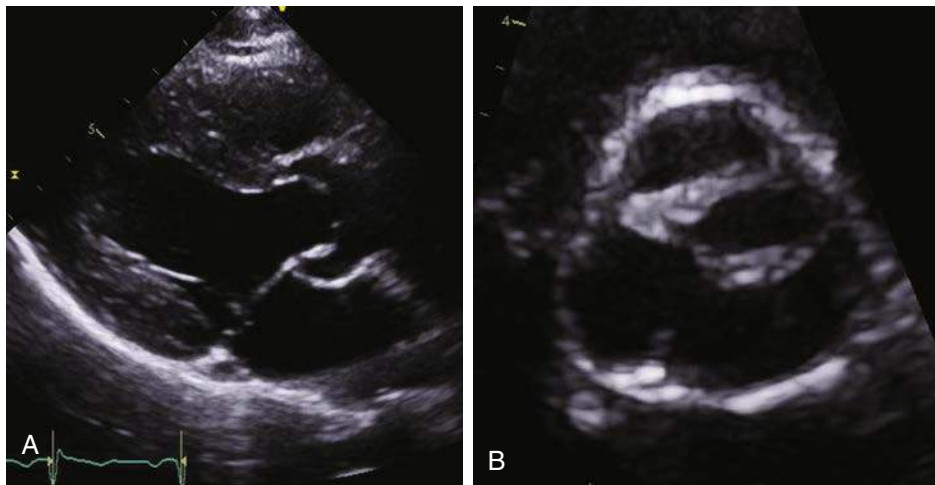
Two-dimensional transthoracic echocardiography (2D TTE) of parasternal long-axis (A) and short-axis (B) views of a bicuspid aortic valve. Valve leaflets are thickened and doming.
